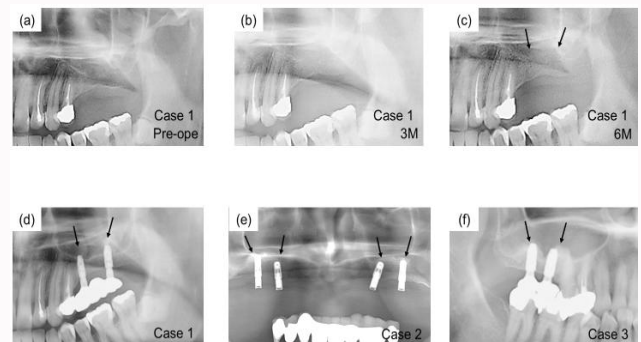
X-ray images after OCP/Col implantation. (a) Immediately after OCP/Col implantation in case 1. There was little radiopacity in the OCP/Col implantation region. (b) Three months after dental implant placement in case 1. The sinus floor had become unclear. (c) Six months after dental implant placement in case 1. Sinus floor augmentation was observed. (d) Twelve months after dental implant placement in case 1 (e) Twelve months after dental implant placement in case 2 (f) Twelve months after dental implant placement in case 3. Arrows show the elevated sinus floor. In each case, the implant body was stable without inflammatory findings.
